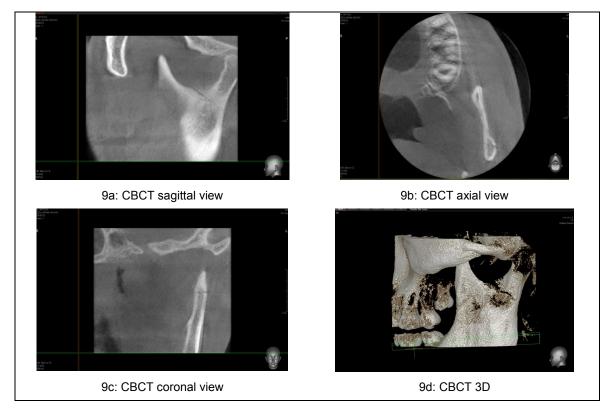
CBCT of mandibular condylar fracture
